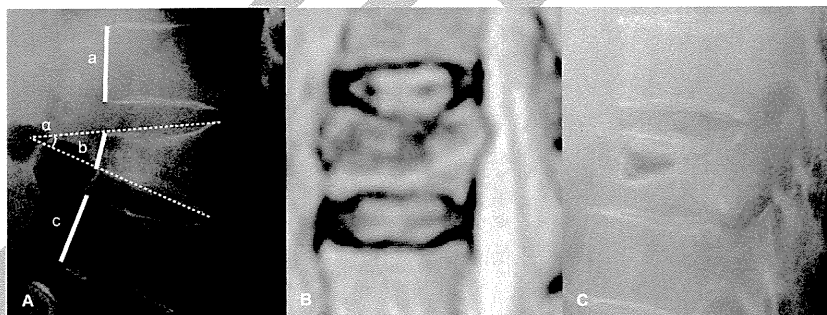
Radiological assessment. A) Anterior vertebral collapsing ratio = $2b/(a+c)$ 100%. Kyphotic angle = α degrees B) Middle column injury of the fractured vertebral body was judged by protrusion of the posterior wall of the vertebral body into the spinal canal on mid-sagittal MRI. C) Non-union was defined as the presence of an intravertebral cleft on plain radiography.
